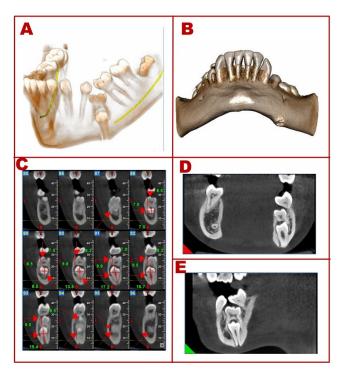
CBCT images depicting the positions of the mandibular premolar; A,B: volumetric frontal view showing the impacted mandibular Premolar is perforating the lower border; C-E: Coronal and Sagittal views showing the position impacted mandibular primary molar and premolar;
